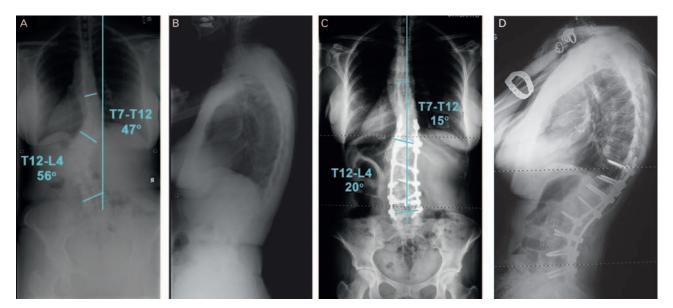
A 61-year-old woman with idiopathic scoliosis. Preoperative anteroposterior (A) and lateral (B) radiographs. (C and D) The patient underwent multilevel XLIF at T12-L1, L1-2, L2-3, L3-4, and L4-5, followed by posterior spinal fusion and instrumentation from T10-L5 with improvements in curve magnitude and balance.
